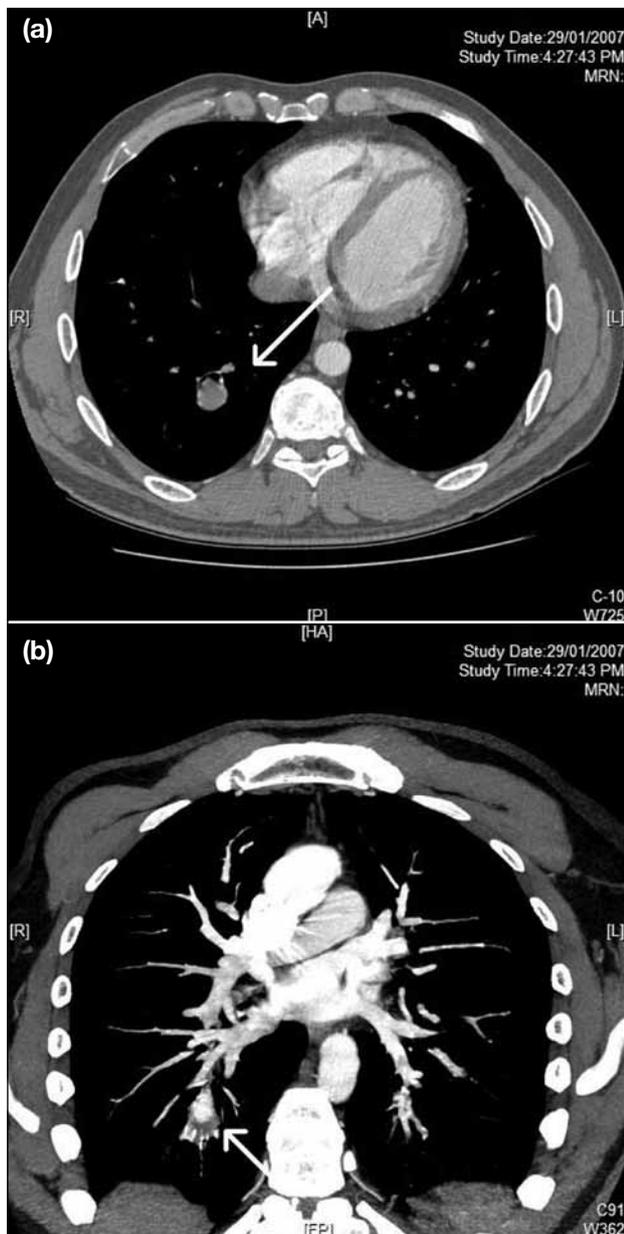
Computed tomographic pulmonary angiography in the (a) axial plane and (b) oblique coronal plane, demonstrating an 18-mm fusiform aneurysm that contains an intraluminal non-occlusive thrombus at the right lower lobe pulmonary artery branch (arrows).
